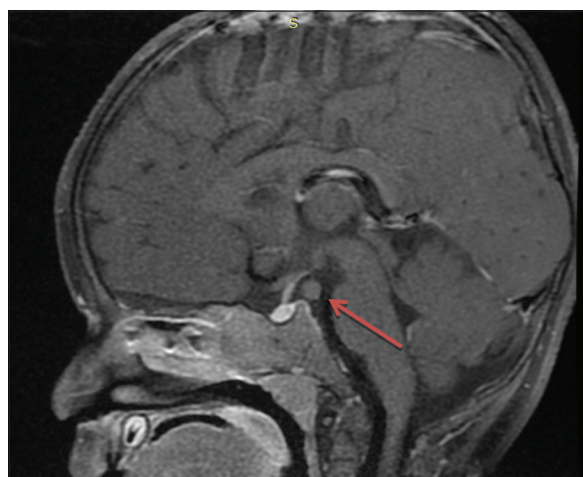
T2-weighted image, post-contrast, and sagittal section showing hypothalamic hamartoma
